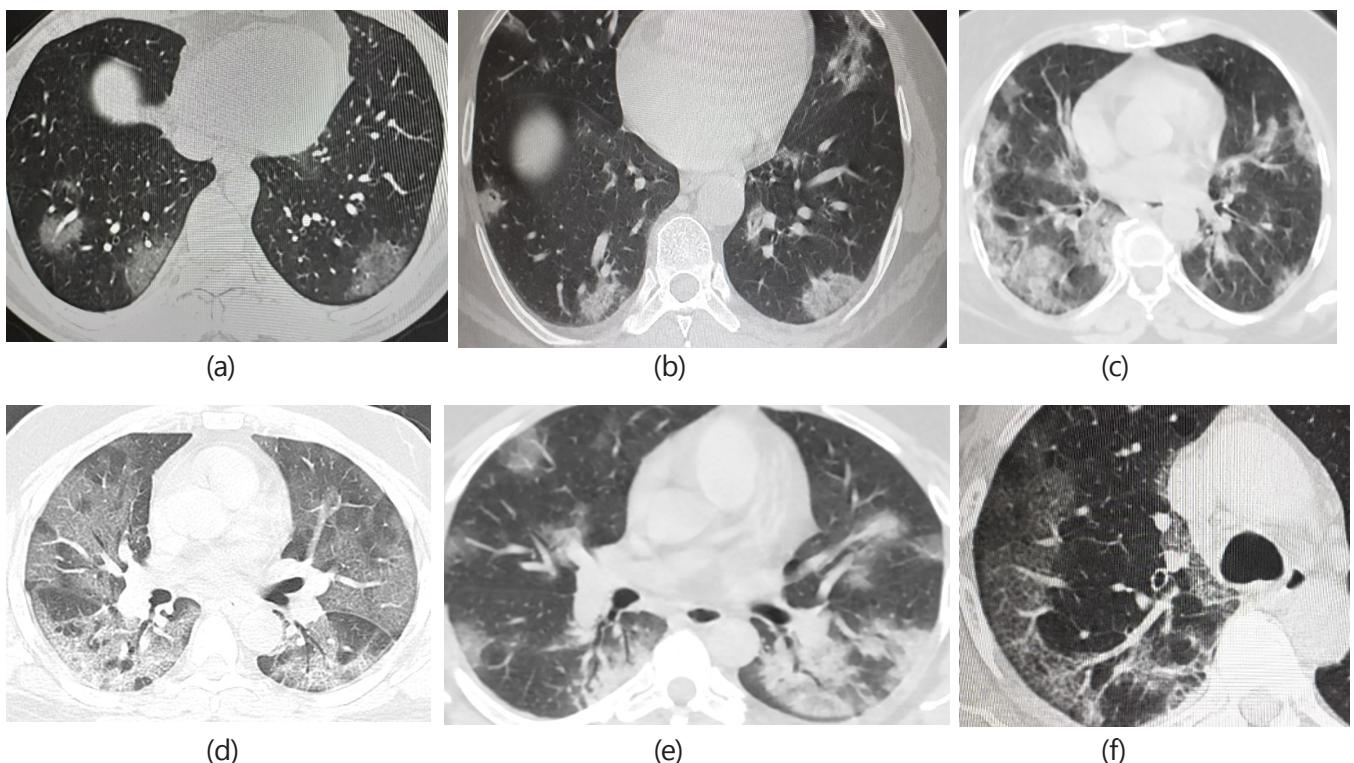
Common HRCT chest findings in a patient with Covid -19 pneumonia: (a) and (b) Axial non enhanced HRCT chest image of 40 yrs old man with covid-19 pneumonia shows multifocal sub pleural areas of Ground glass opacities having a lower lobe predominance. (c)Axial non enhanced HRCT chest image of 54 old females with covid-19 pneumonia shows consolidatory changes in bilateral lung fields mimicking reverse batwing appearance. (d)Axial non enhanced HRCT chest image shows extensive bilateral lower lobe ground glass opacities with associated Inter lobular septal thickening described as the crazy paving pattern. (e) Axial non enhanced HRCT chest image shows air bronchogram within the area of consolidation in a patient with Covid-19 pneumonia. (f) Axial non enhanced HRCT chest image shows enlarged vascular channels in areas of ground glass opacities in a patient with covid-19 pneumonia.
